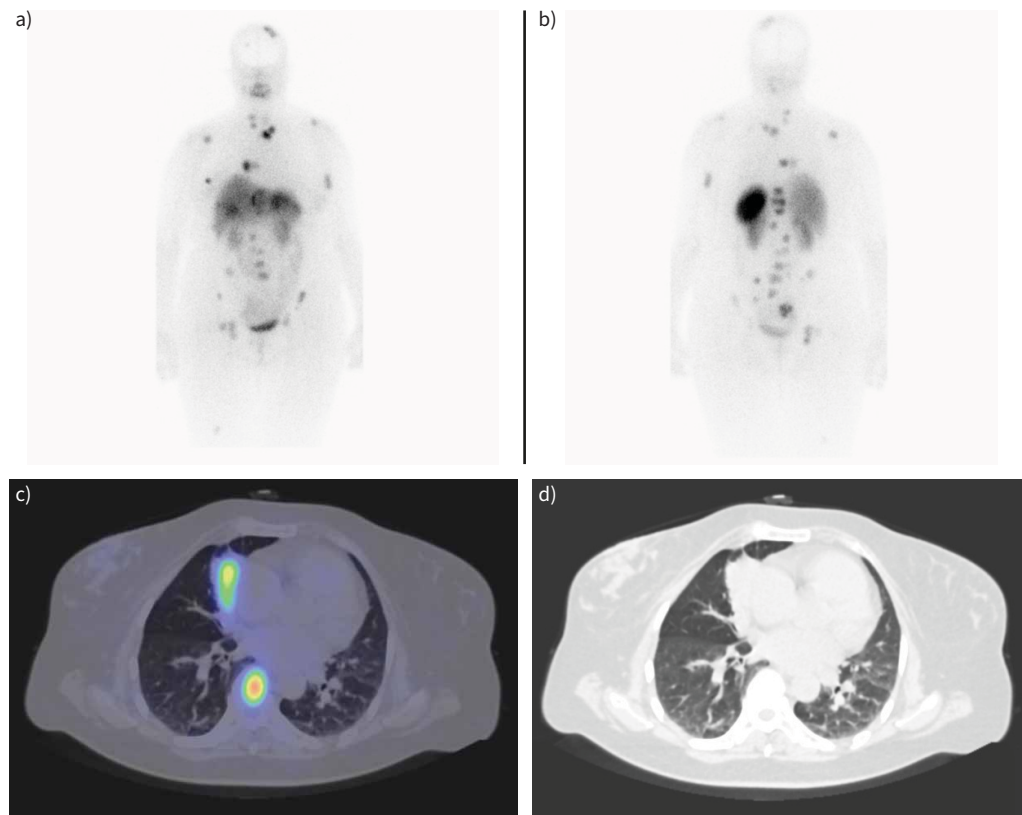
A 54-year-old female patient diagnosed with a lung carcinoid tumour underwent somatostatin receptor scintigraphy using a technetium-99m (^{99m}Tc)-labelled somatostatin analogue. a) Anterior and b) posterior whole body planar images display the primary tumour in the right lung, as well as solitary hepatic and breast metastasis and multiple bone metastases. c) Fused and d) computed tomography (CT) images from single-photon emission computed tomography (SPECT)/CT imaging of the patient depict the primary tumour in the middle lobe of the right lung and bone metastasis in the body of the seventh thoracic vertebra.
